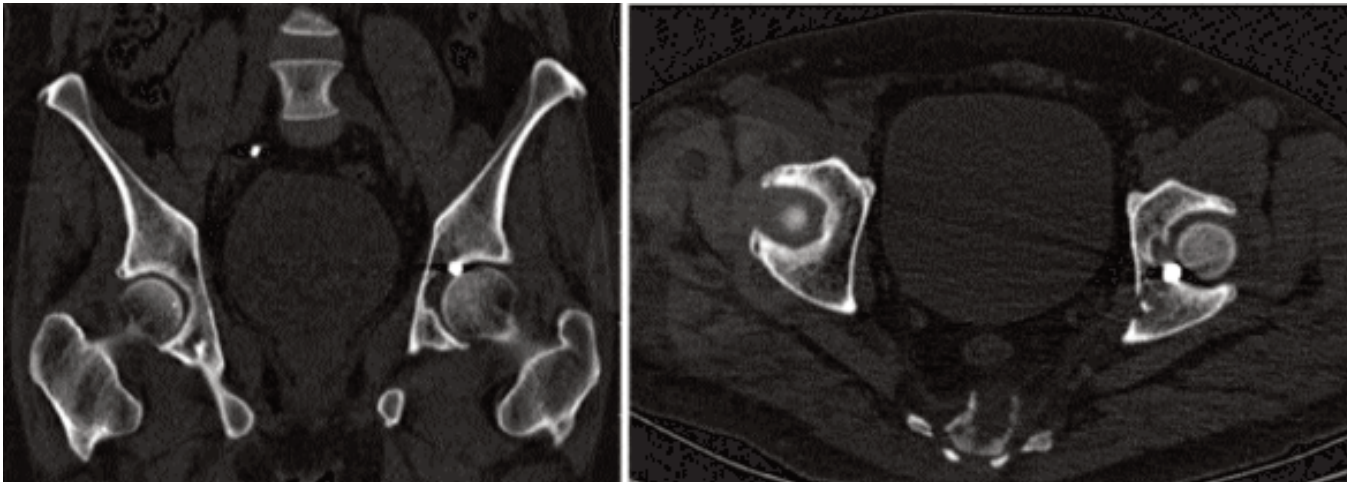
CT images of intra-articular bullet in the hip joint.
